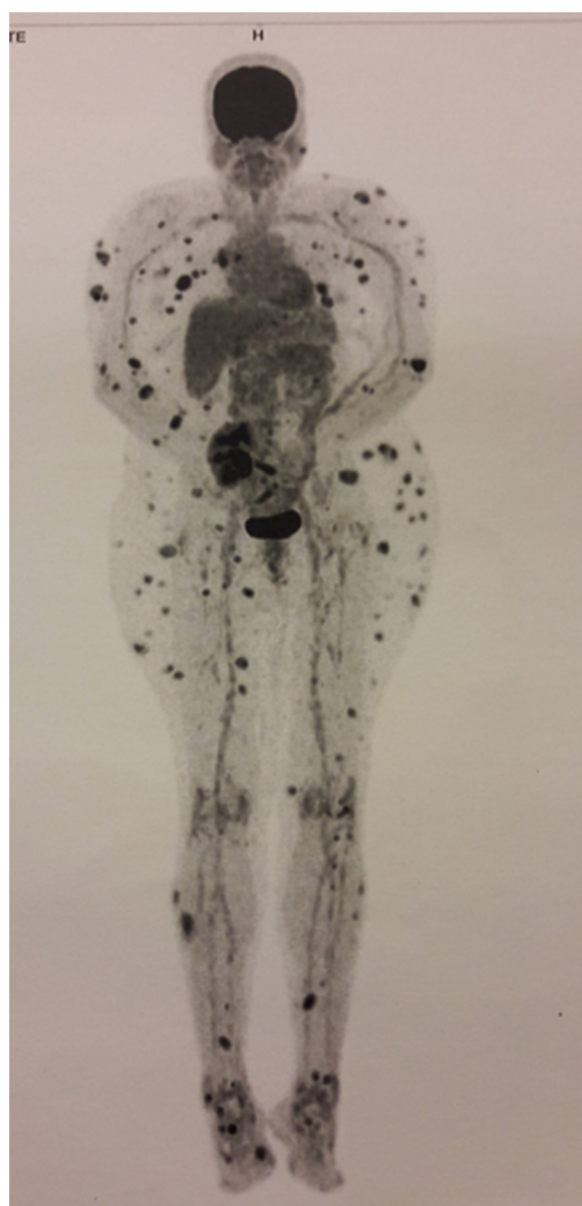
PET/CT scanning, revealing FDG-avid cutaneous and sub-cutaneous nodules, mediastinal lymphnodes and left pulmonary infiltrate.
